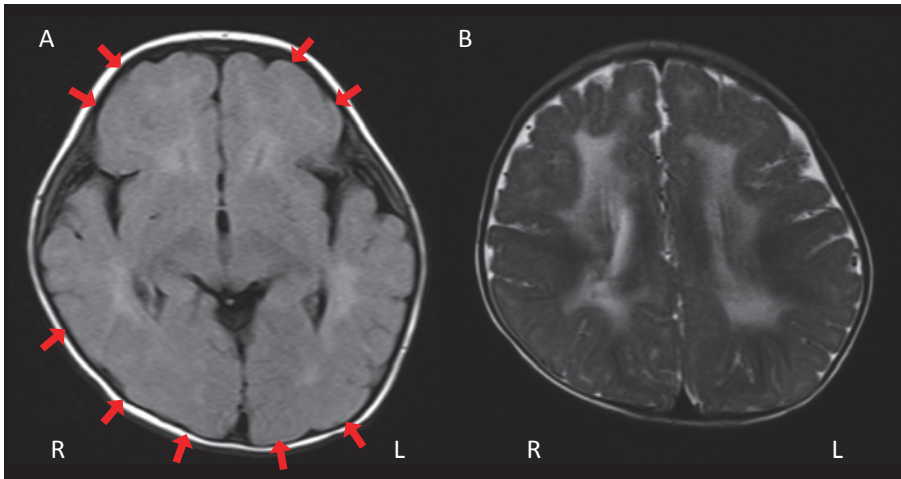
(a) FLAIR image showing pachygyria (red arrows) in frontotemporal and occipital cortices. (b) T2-weighted image showing symmetrical high intensity in the white matter
